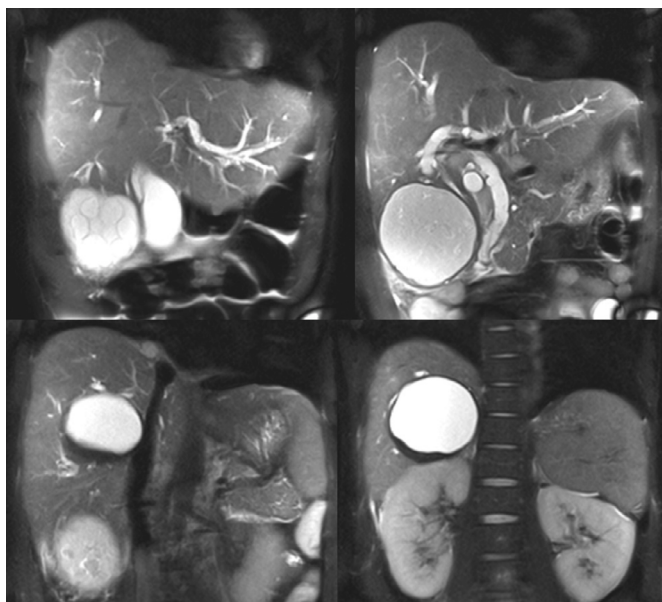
MR imaging of hydatid cysts and dilated intrahepatic biliary tracts.
